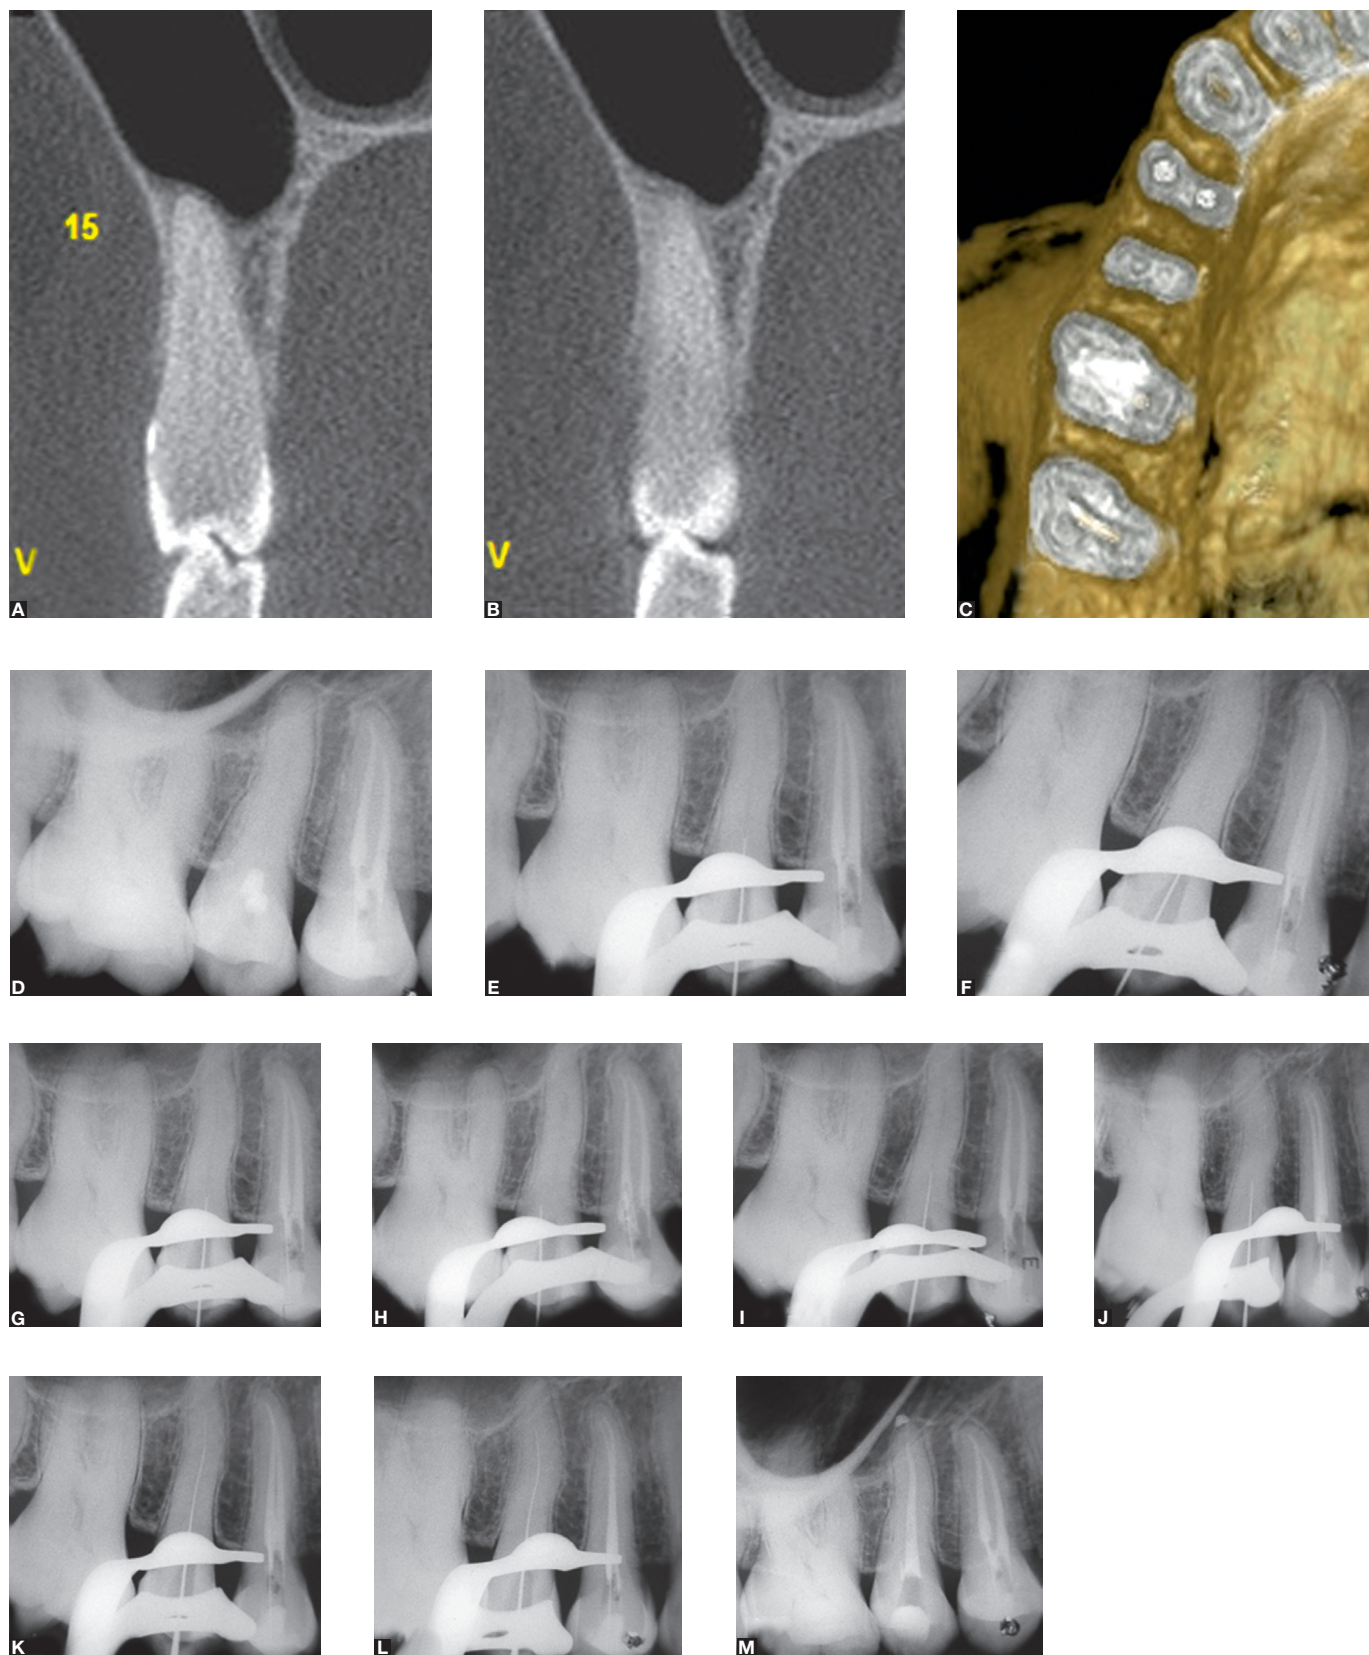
(A-C) Preoperative CT and radiograph. (D) Centered radiograph. (E) In the angulated radiograph, the file seems to be mesially dislocated. (F) After correction in the position of the file, it was inserted 1-2 mm apically. In the centered radiograph the file seems to be in the correct position. (G) However, the angulated radiograph shows that the file is palatally dislocated. (H) After new correction, the file was inserted 1-2 mm apically. (I) The angulated radiograph shows the file in the correct position. (J,K) The file reached the root canal space. (L) Obturation done.
